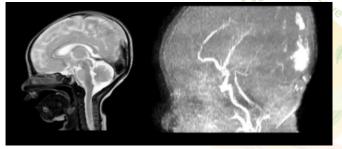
Postnatal MRI: Sagittal views of the thrombus at Torcular Herophilus
